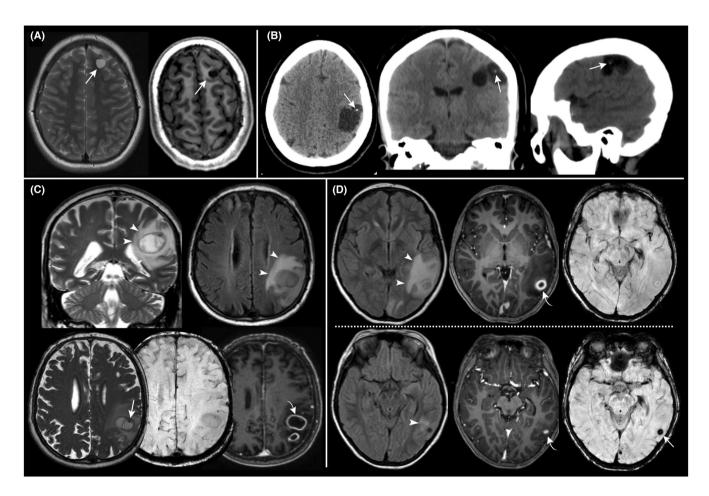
Examples of early-stage NCC lesions. (A) Vesicular lesions in the left frontal lobe (arrows). The interior of the lesion shows intensities similar to CSF in T2-(left) and T1-(right) weighted images. (B) The scolex can be identified on CT as a hyperdense spot within a large hypodense cyst ("hole-with-dot"; arrows). (C) Large temporo-parietal vesiculo-colloidal lesions with visible scolex (arrow), considerable perilesional edema (arrowheads), and signal enhancement of the capsule (curved arrow). (D) Temporal evolution in a patient showing a large vesiculo-colloidal lesion (top) that is greatly reduced after treatment (bottom), with near-complete resolution of edema on FLAIR (left; arrowheads), subtle post-contrast enhancement (middle; curved arrows), and visible calcification on SWI (hypointense, right; arrow).
